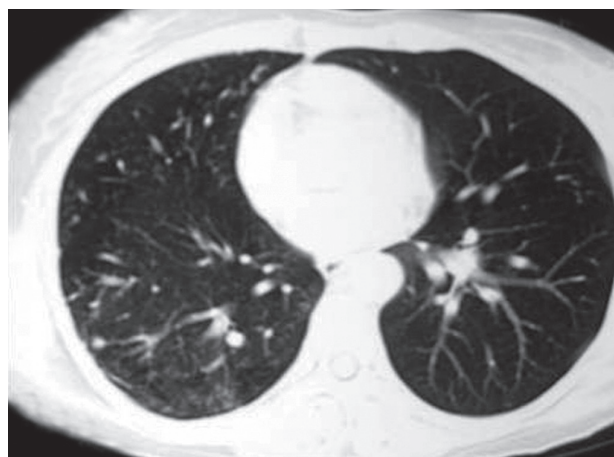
High-resolution CT chest showing nonhomogenous opacities in perihilar region
